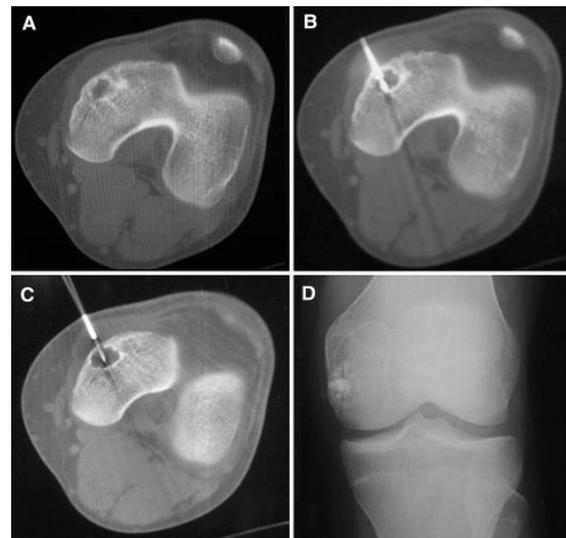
A) CT scan showing tumour in the distal femoral epiphysis B) Biopsy needle within tumour C) Electrode within the tumour D) Image after RFA and cementation [6]
